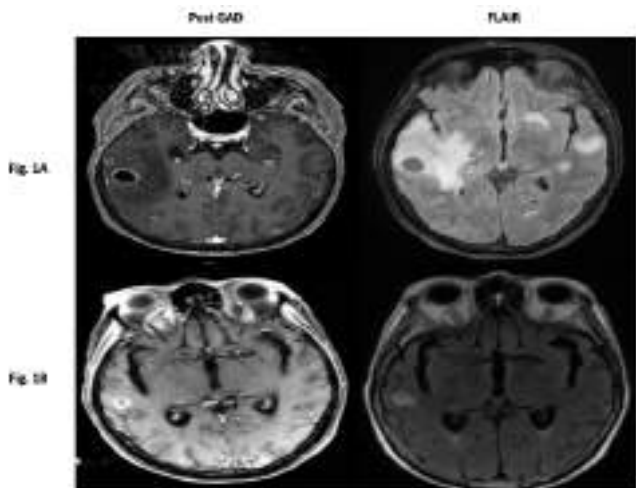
Brain magnetic resonance imaging, pre-treatment baseline post GAD an FLAIR sequences are shown (Fig.1A), followed by near complete resolution of two posterior fossa lesions and associated edema, and significant reduction in tumor volume of a right lateral temporal lobe lesion after 1 month of lorlatinib therapy (Fig.1B)
